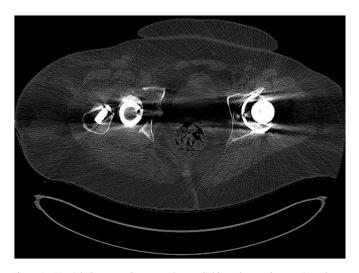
CT coronal plane cuts demonstrating medial bone loss to the anterior column. CT, computed tomography.
